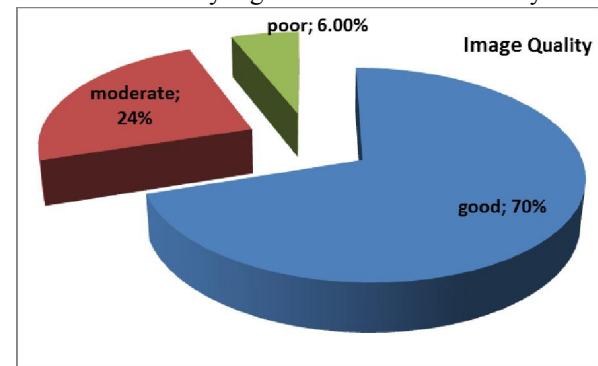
3D chart showing distribution of different CT image qualities.
